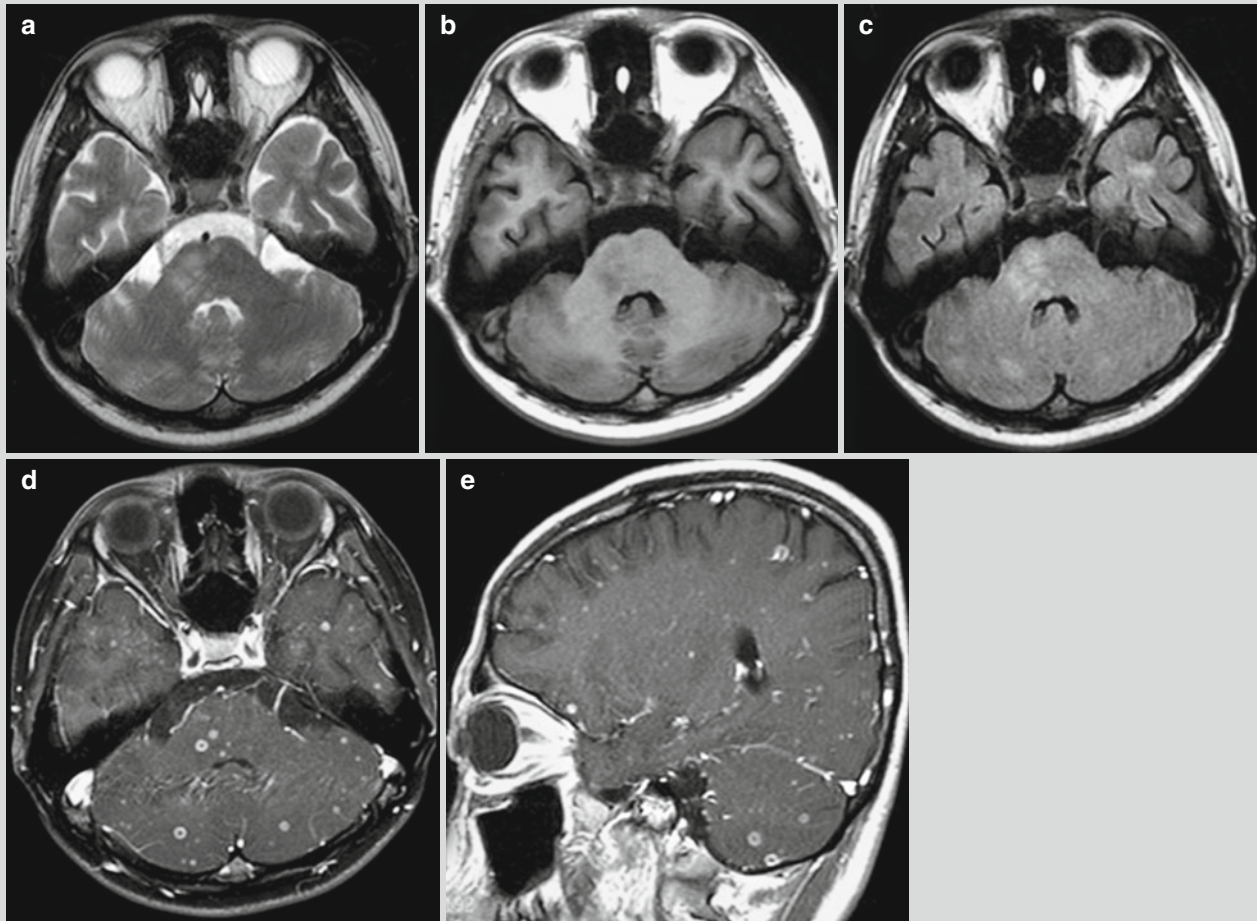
Cerebral tuberculosis. (a–c) MR imaging demonstrates slightly long T1 slightly long T2 signal of patches of shadows at the brainstem, cerebellum, and left temporal lobe, with poorly defined
